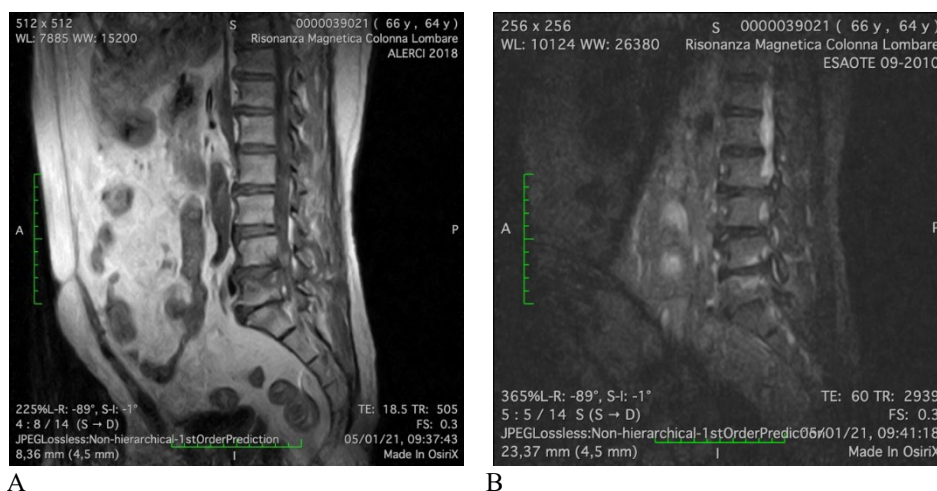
66 years male with chronic LBP from 3 years. Sagittal T1SE scan (A) and sagittal T2STIR (B) images. On MRI a mixed type I and II Modic degeneration can be appreciated at the level of the subcondral somatic bone at L4 and L5, in correspondence to the focal pain referred.
